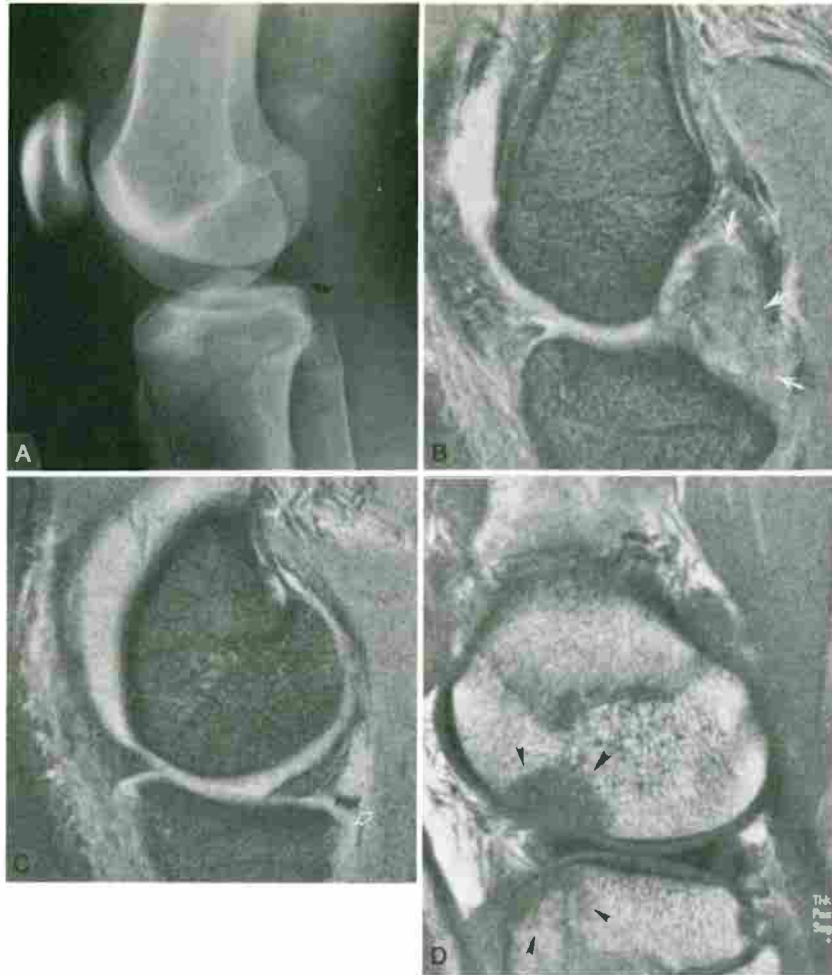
Complete tear of posterior cruciate ligament (PCL) with avulsion fracture at the tibial insertion site. A, Lateral radiograph of the knee demonstrates a joint effusion (asterisk) and a subtle fleck of bone (black arrow) adjacent to the posterior tibial rim. Sagittal gradient-echo (TR/TE, 442/18; angle, 30 degrees) images through the intercondylar notch (B) and through the lateral aspect of the medial joint compartment (C) show a cloud of edema and hemorrhage (white arrows) without recognizable ligamentous fibers in the expected course of the PCL and the small avulsion fracture (open white arrow) off the tibial attachment of the PCL. D, Sagittal T1-weighted (TR/TE, 430/20) image through the lateral joint compartment demonstrates femoral impaction fracture and bone contusion (arrowheads) of the anterior aspect of the lateral femoral condyle and lateral tibial plateau resulting from the hyperextension injury.
